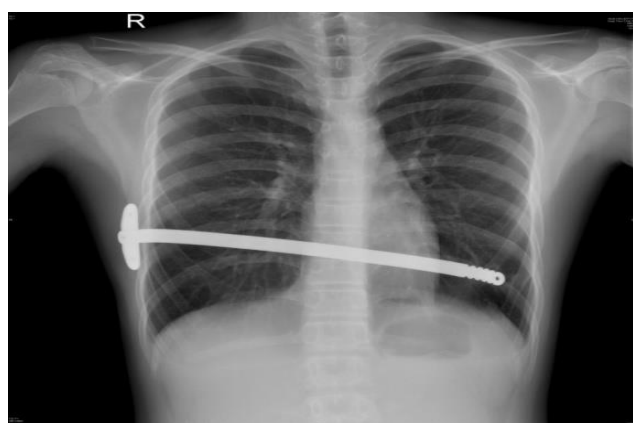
Chest radiograph indicating dislodgement of the supporting bar after pectus repair with slight migration towards the left hemi diaphragm.
